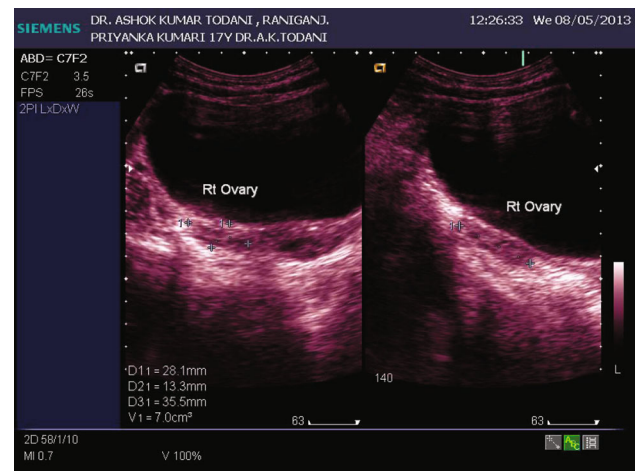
Transabdominal pelvic ultrasound (right ovary)
